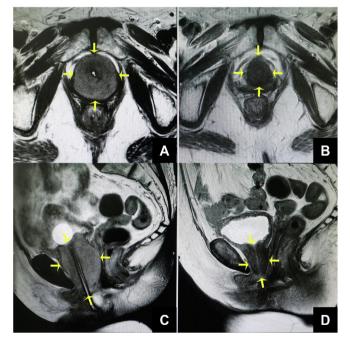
T2-weighted MRI pelvis compared between before and after treatment, (A and C) were cross-section and sagittal view at the time of urinary retention. The mass was $6.2 \times 4.4 \times .4.2$ cm. in size. (B and D) were cross-section and sagittal view after treatment. The mass was significantly decreased and measured $3.0 \times 2.2 \times 2.4$ cm. in size.
